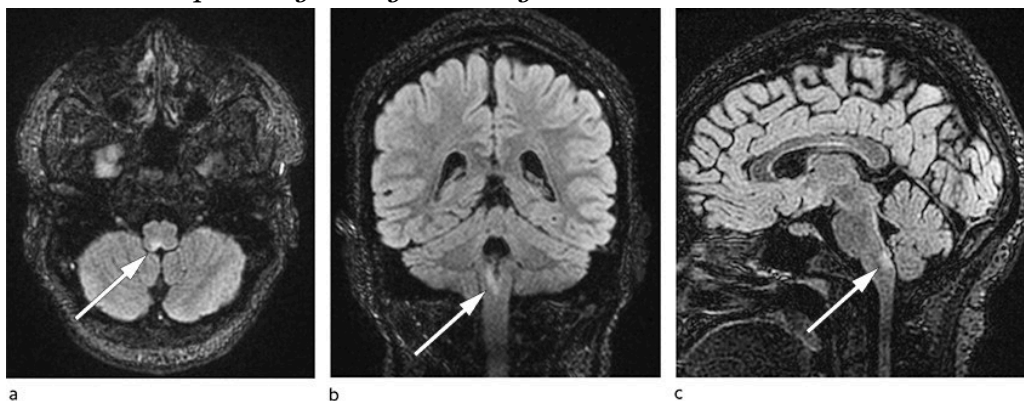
Representative MRI images of lesion in the area postrema: T2-FLAIR in axial (a) coronal (b) and sagittal (c) planes.
